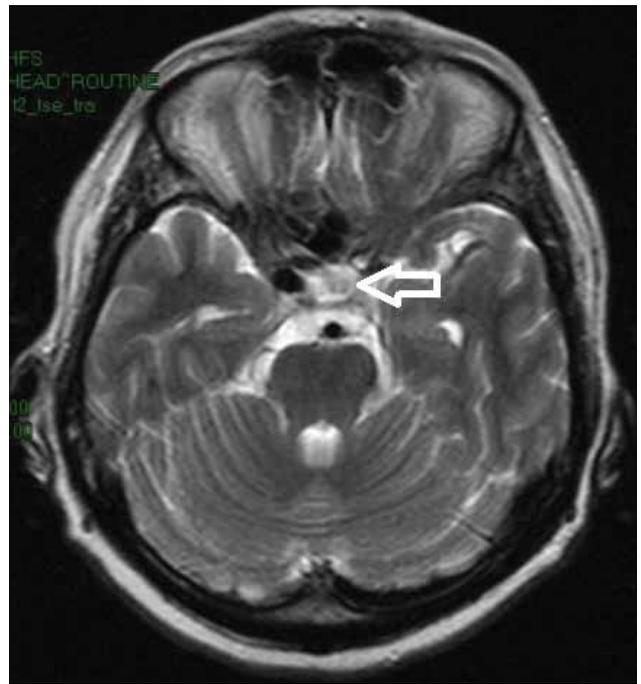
T2 Hyperintense round mass, with a vascular trajectory and calcifications, intracavernous and interpeduncular corresponding to the area observed on the brain CT scan
